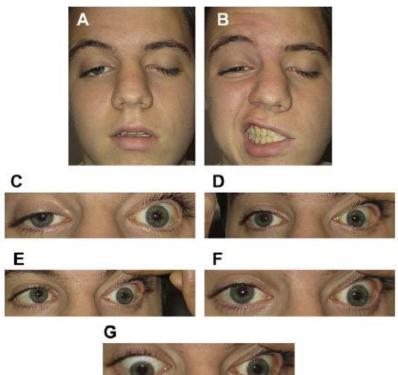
A 15-year-old boy with multiple idiopathic cranial neuropathies who presented with 3 days of diplopia and facial weakness. There was hyporeflexia and mild ataxia in the arms. Brain MRI was normal and spinal fluid revealed 1 leukocyte and normal protein
